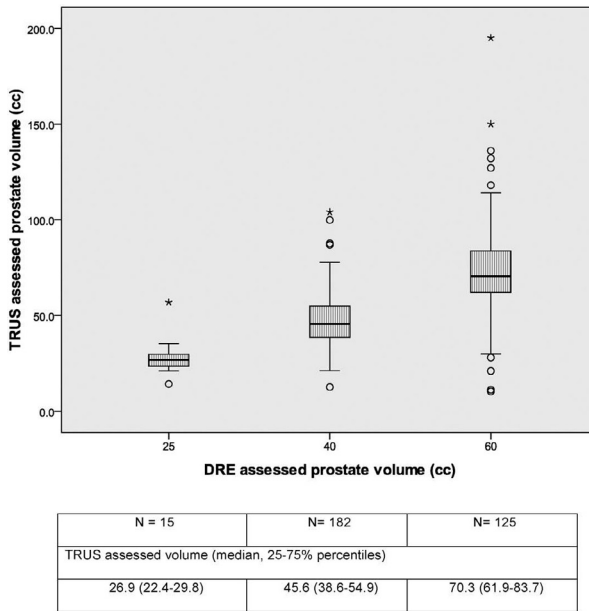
Box plots of prostate volume assessed by transrectal ultrasound (TRUS) per digital rectal examination (DRE)-assessed prostate volume class
